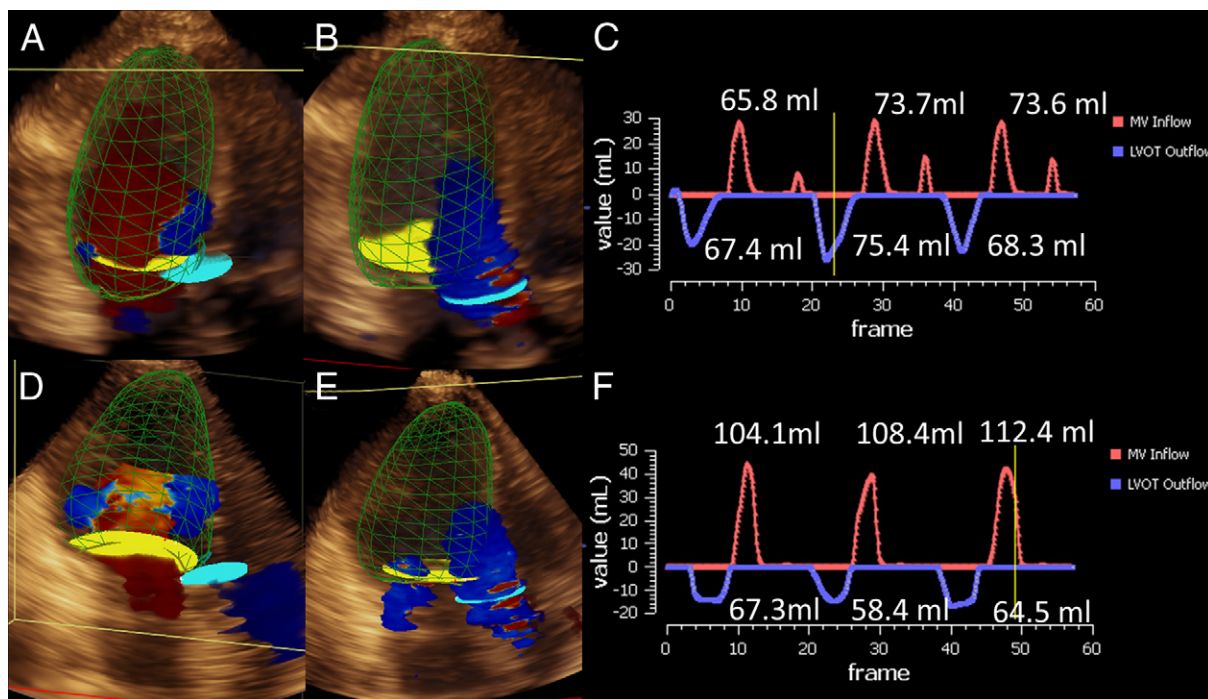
3D Color Doppler Based Stroke Volume Quantification
